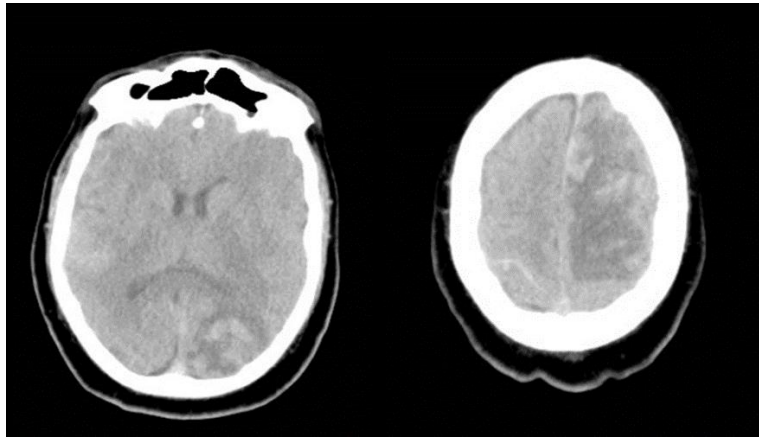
At the 48th hour after the clinical onset, the CT scan of the brain with intravenous contrast enhancement that was performed, showed the highest diagnostic value. Bilateral hemorrhages in the subarachnoid space, cerebral edema with dislocated interhemispheric fissure, with expansion of the extensive two hypodense zones with hyperdense central foci with a density of 65 HU parietally and parietooccipally were visualized.
